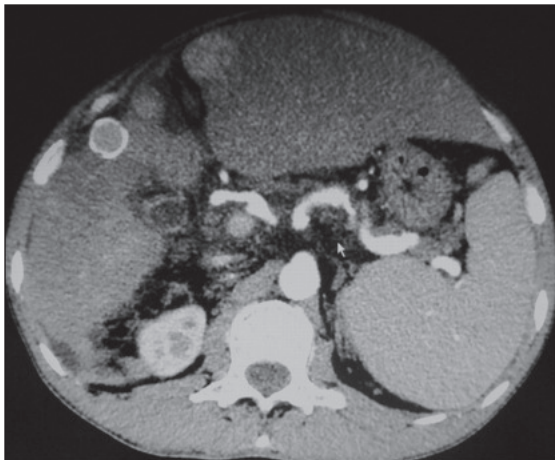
Contrast-enhanced computed tomography scan showing multiple, small, hypervascular lesions.
